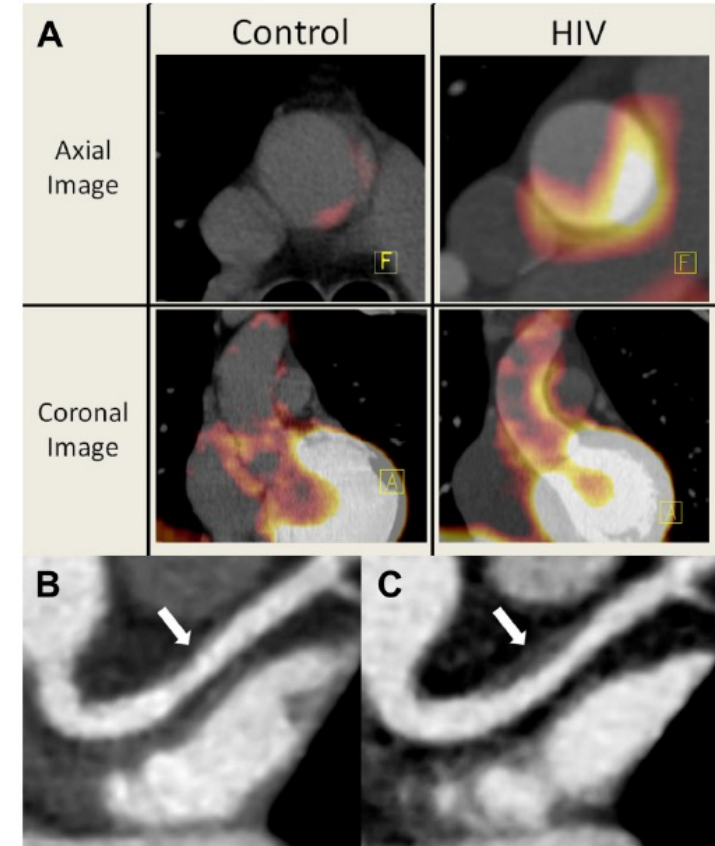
FDG/PET and Coronary Computed Tomography Angiography Images of Arterial Inflammation and Non-Calcified Plaque Progression in HIV patients
